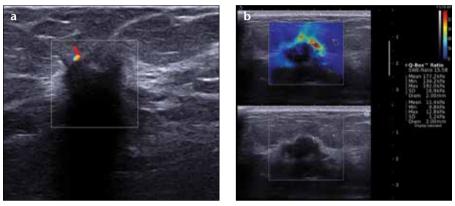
a, b. Gray-scale and color Doppler ultrasonographic evaluation of a BI-RADS V lesion that proved to be a grade II invasive ductal carcinoma (a). Peripheral vascularization was evident on color Doppler imaging. Evaluation via shear wave elastography (b) showed that the maximum areas of stiffness were almost always located in the peritumoral stromal regions, and we thus placed the ROIs in these regions. Stiff areas were found only at lesion peripheries, and were coded red-yellow. Lesion centers were almost pure blue in color. The ROI of the breast fat tissue was of the same dimensions as the corresponding lesion. Mean lesional elasticity, 177.2 kPa; mean elasticity of fat tissue, 11.4 kPa; mass/fat ratio, 15.58; ROI diameter, 2 mm.
